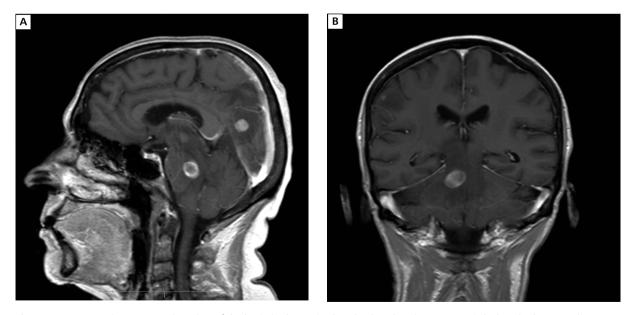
A. Magnetic resonance imaging of the brain in the sagittal projection showing metastatic lesions in the central nervous system located in the right parietal region near the cerebellar falx and on the border of the pons; B. Magnetic resonance imaging of the brain in the frontal projection showing metastatic lesions in the central nervous system located on the border of the pons and in the right frontoparietal area
